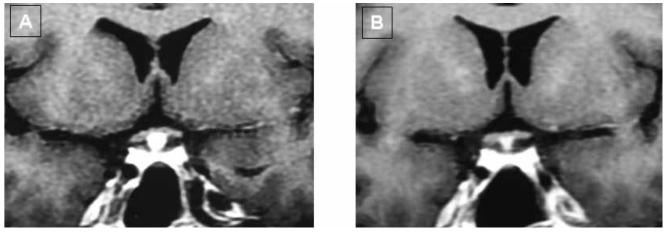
Effects of methylprednisolone pulse therapy on pituitary stalk thickness. (A) MRI revealed obvious thickening in pituitary stalk before therapy. (B) After 2 weeks methylprednisolone pulse therapy, pituitary stock thickness was reduced.
